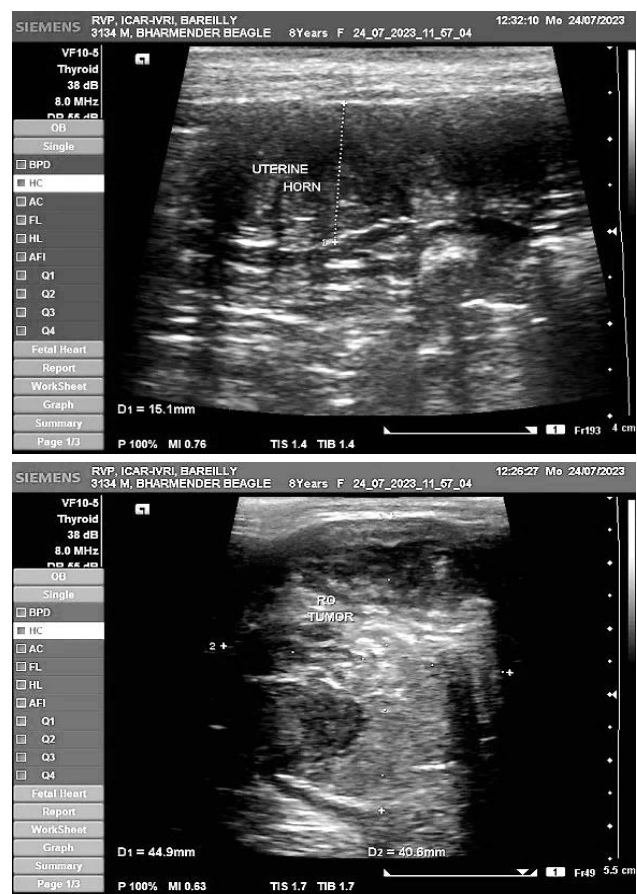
(a) Sagittal sonographic image of ovarian granulosa cell tumour (between callipers) with heterogeneous parenchyma; (b) Sagittal sonographic image, showing an enlarged uterus (between callipers) with cystic endometrial hyperplasia was identified as the presence of multiple small cyst-like lesions throughout the uterine wall.
